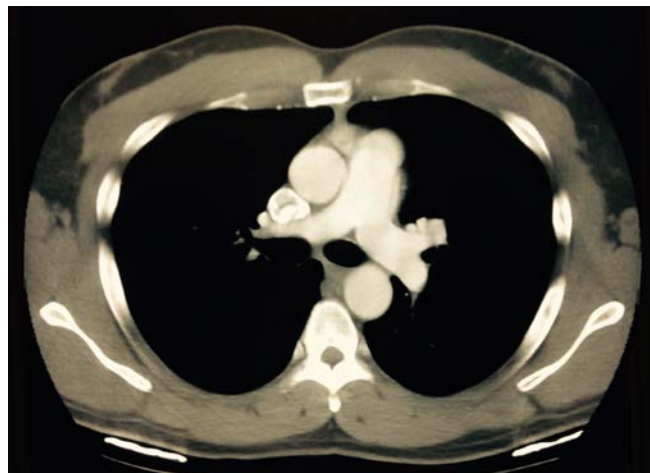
Axial CT image of the chest displayed in a soft-tissue window setting.
